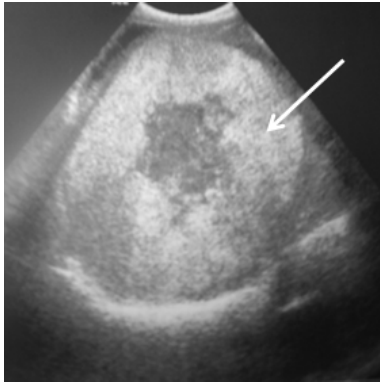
Abdominal ultrasound: Bulky heterogeneous tumor of the left lobe of the liver
